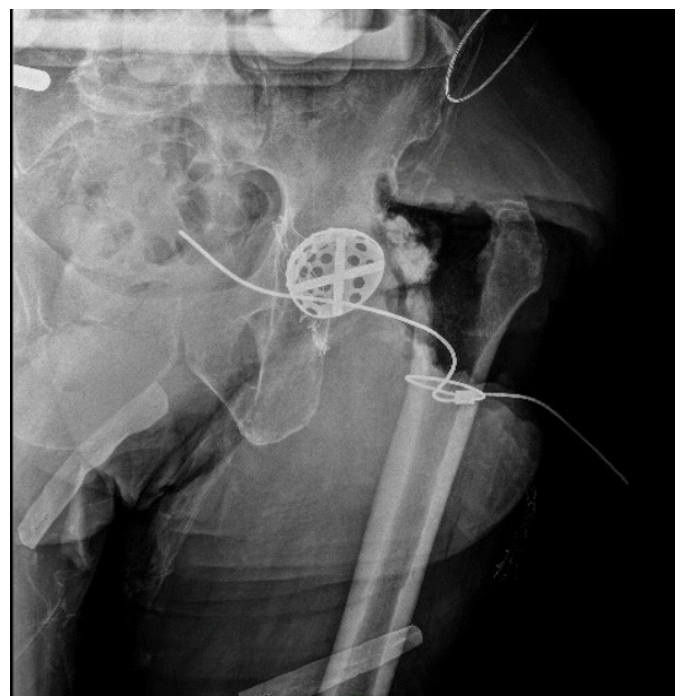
Intraoperative X-ray confirming identification of anatomic acetabulum. Intra-operative AP radiograph utilizing a reamer shell to confirm correct identification of the anatomic acetabulum.
